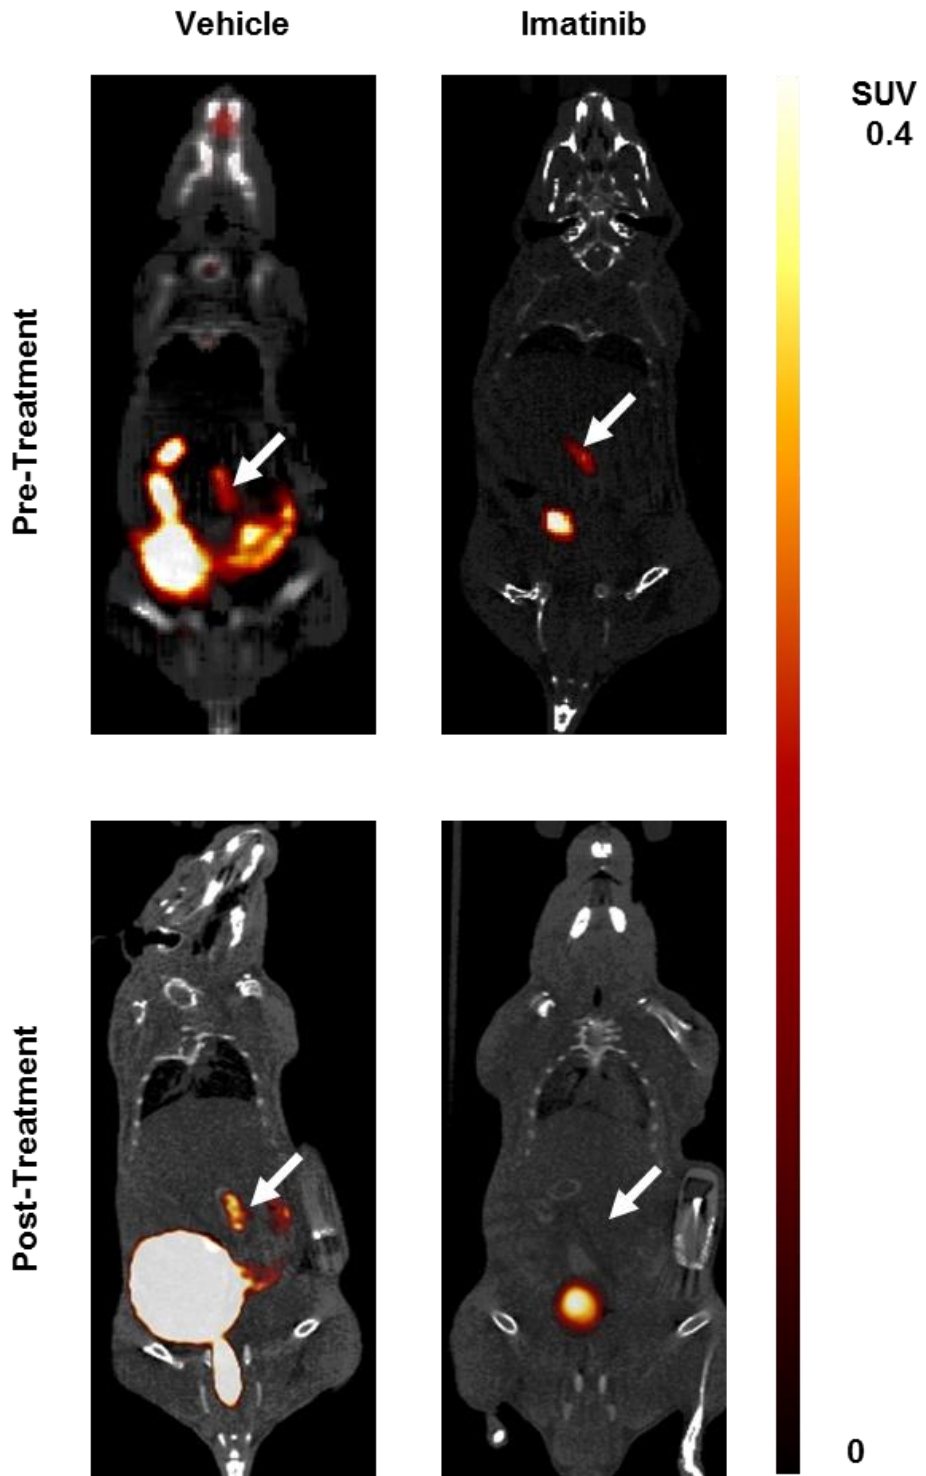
[^{18}F]FLT uptake in AngII AAA decreased following imatinib treatment. Coronal-view PET/CT images of static abdominal aortic uptake of [^{18}F]FLT 80–100 min post-radiotracer injection pre- and post-treatment with imatinib or vehicle (tap water). Arrows indicate the abdominal aorta. Colour scale bars indicate SUV thresholding to aid visualisation.
